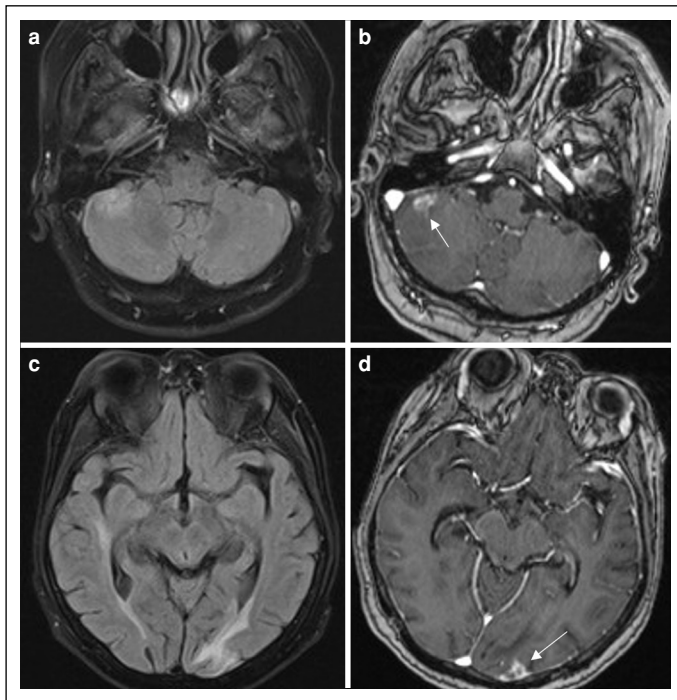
Brain MRI of the patient at the time of presentation with cranial symptoms. Fluid inversion recovery (FLAIR) images show focal right cerebellar (a) and left occipital (c) edematous hyperintensities which are due to patchy enhancing cortical lesions seen in post-contrast T1-weighted (w) images (arrows in b and d, respectively).
